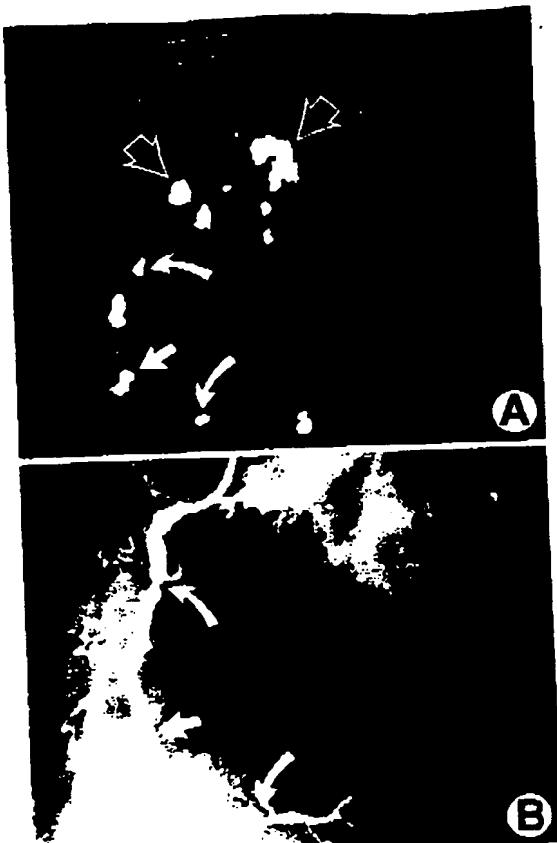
Identification of calcific atherosclerosis by ultrafast computed tomography (CT) (A) and by cardiac catheterization (B). Lesions were observed using both techniques. The coronary artery lesions resulting in >50% luminal diameter stenosis of the left right coronary artery as defined by angiography in the left anterior oblique position are highlighted by the solid, curved white arrows (B). The three-dimensional image of the heart of this same patient in the same orientation was able to place calcification of these same stenotic lesions, again highlighted by the solid curved white arrows (A). A lesion that partially encroached on the lumen as seen by angiography was also detected by CT (straight white arrow). However, the extent of nonocclusive atherosclerosis was more fully evident in the CT image than in the angiographic image, since ultrafast CT detected calcific lesions in both the right coronary artery and the coronary ostia (A; open arrows), which are not apparent by coronary arteriography. In the angiogram, for example, there is a hint of luminal irregularity that does not reach critical stenosis (B; short, solid arrow) but is detected by CT.
